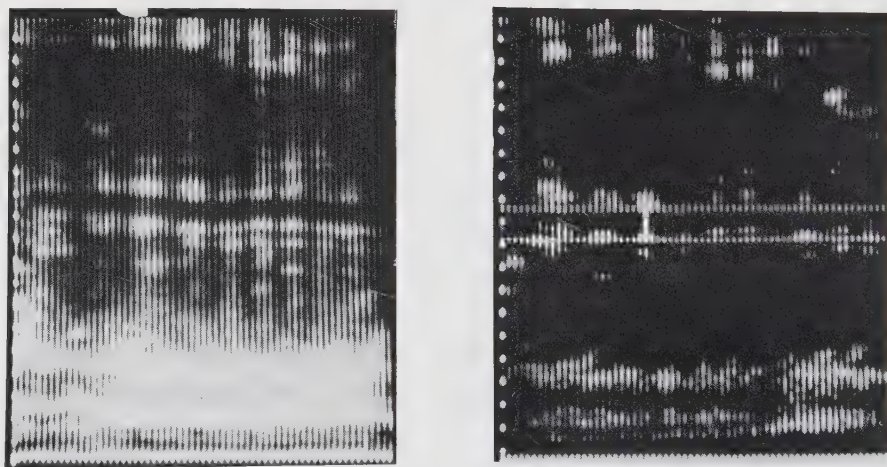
(Left) Ultrasonic image of a segment of the descending aorta in a fetus at 36 weeks of gestation. (Right) The same image including the echo-tracking function. The two horizontal marker lines for tracking the aortic walls and the intensified vertical line representing the instantaneous vessel diameter are shown.
